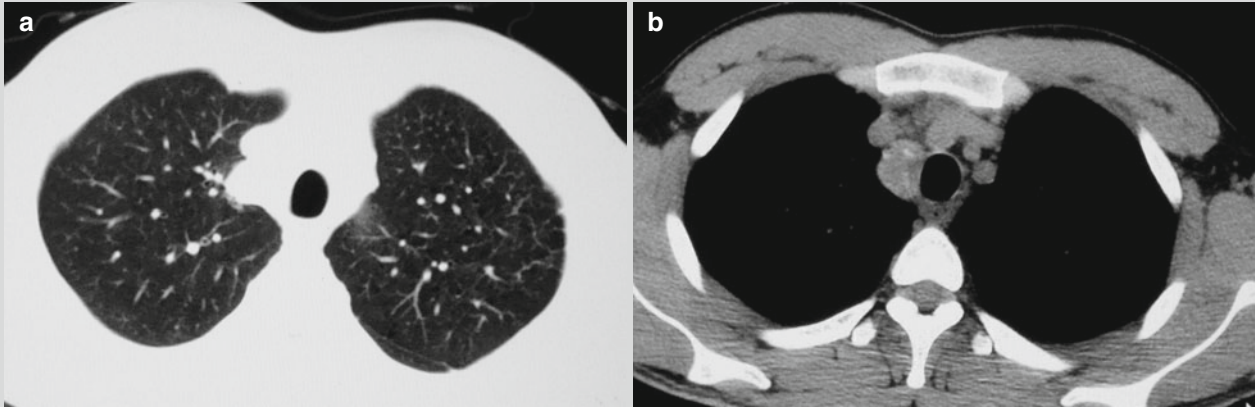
Mediastinal lymphatic TB. (a) CT scanning demonstrates paratracheal nodular shadow at the right upper mediastinum, which is in arch shape protruding towards the lung field. (b) The
